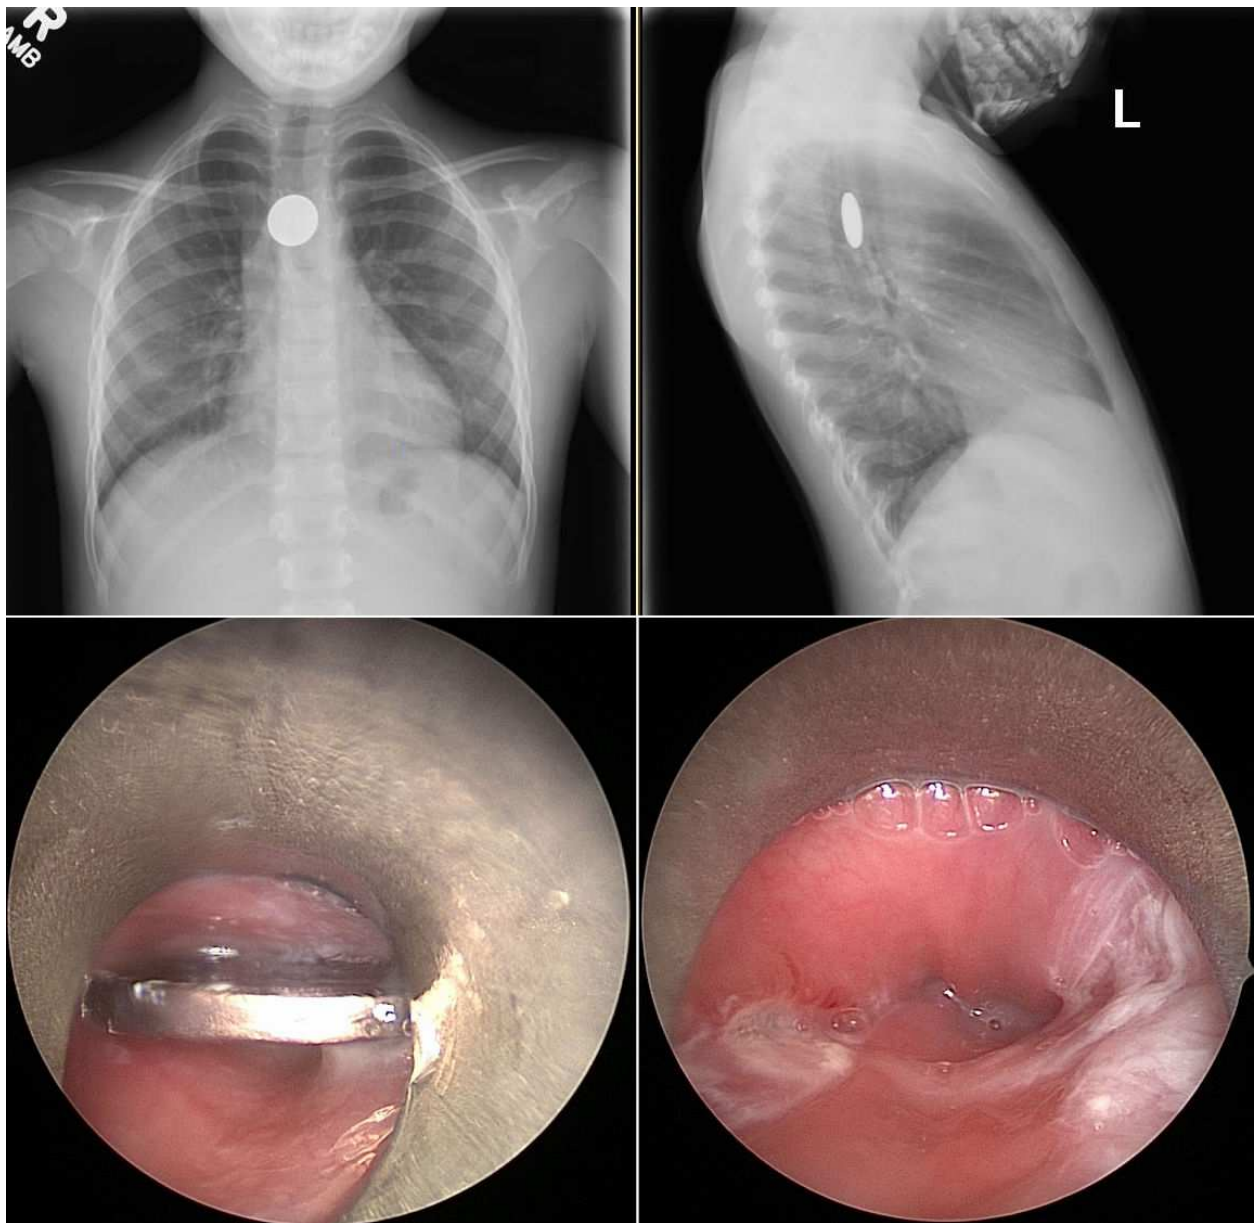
A 5-year old presented to the Emergency Department with several episodes of emesis. She admitted to swallowing a penny while at day care earlier that day. A-P and lateral plain films confirmed the diagnosis of an esophageal foreign body. A penny was identified and removed via rigid esophagoscopy. Minimal esophageal mucosal irritation was noted.
